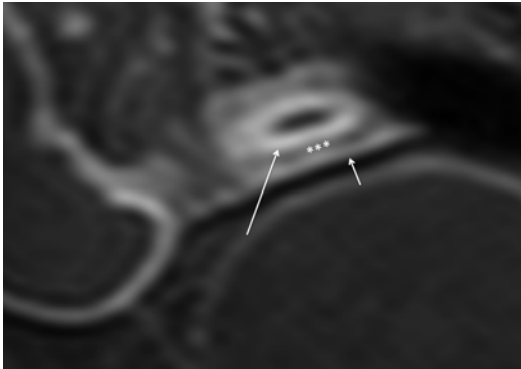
Pattern I of mural enhancement – mucosal hyperenhancement in active Crohn's disease. Magnified sagittal GE T1-weighted fat-saturated image, obtained after i.v. injection of gadolinium, shows hyperenhancement of intestinal mucosa (*arrows*), as a sign of active inflammation
